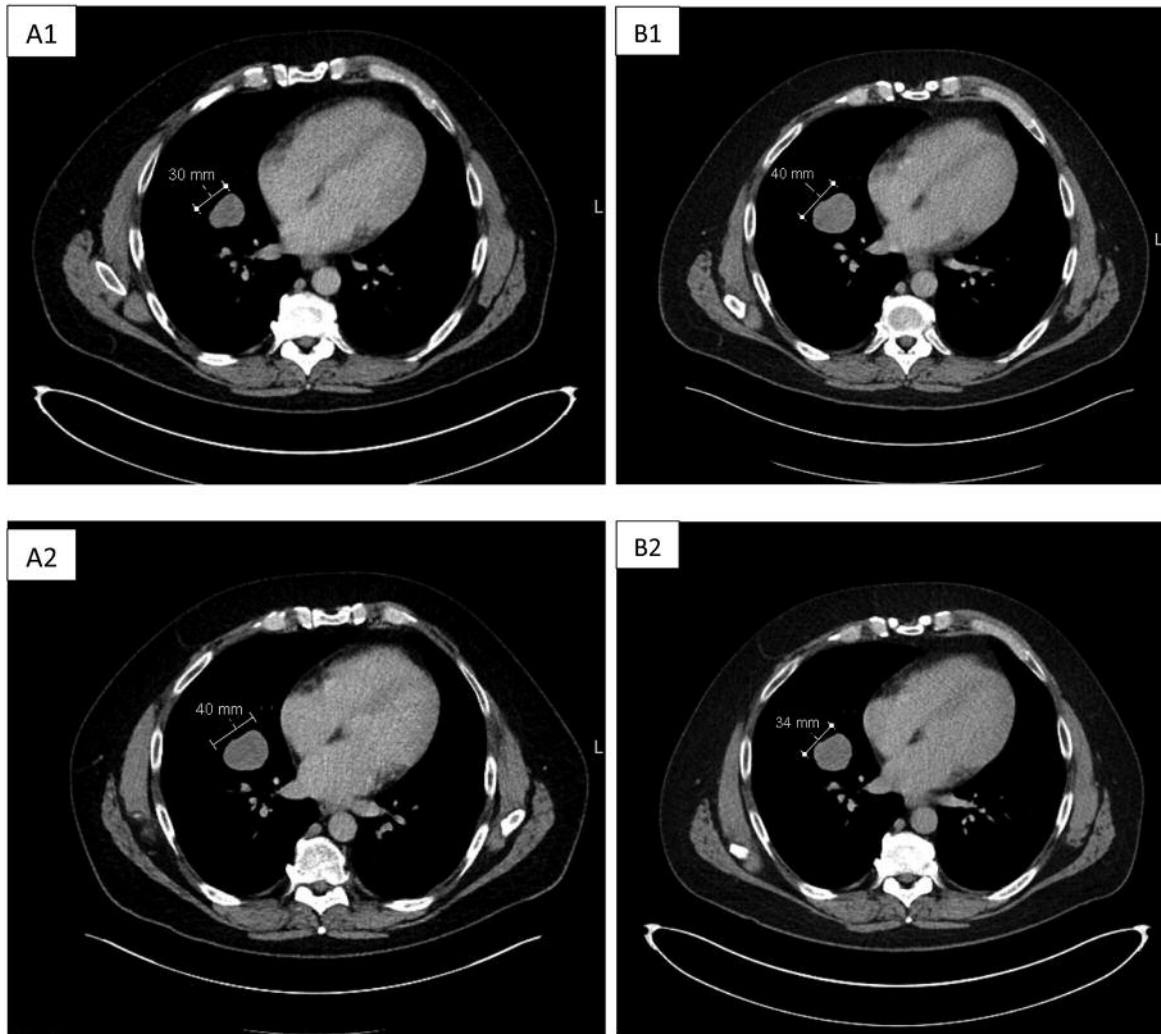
Computer-tomography (CT) images from patient 1. A) Baseline images prior to treatment with gemcitabine-dacarbazine chemotherapy demonstrating increase in size of the tumour (A1 – baseline scan, A2 – most recent scan). B) Images during treatment with gemcitabine-dacarbazine chemotherapy showing a response to treatment with a reduction of the tumour (B1 – baseline scan at the start of treatment with gemcitabine; B2 – most recent scan).
